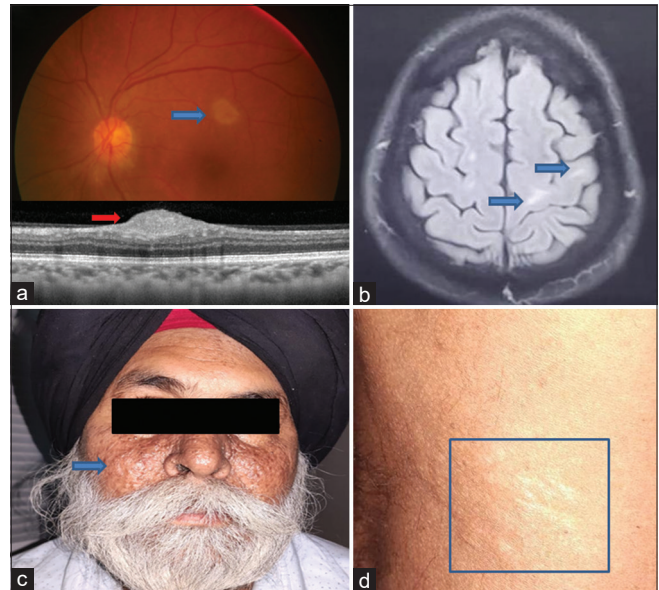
(a) Fundus picture of the left eye showing retinal astrocytoma (blue arrow), hyperemic disc, and corresponding swept-source optical coherence tomography B scan showing dome-shaped lesion arising from the inner retina (red arrow). (b) Axial section of MRI brain in fluid-attenuated inversion recovery sequence showing subcortical linear hyperintense signals along the left precentral gyrus of the frontal lobe likely to represent cortical tubers (blue arrows), (c) showing facial angiofibromas/adenoma sebaceum (blue arrow), and (d) showing shagreen patch on the back (blue square)
